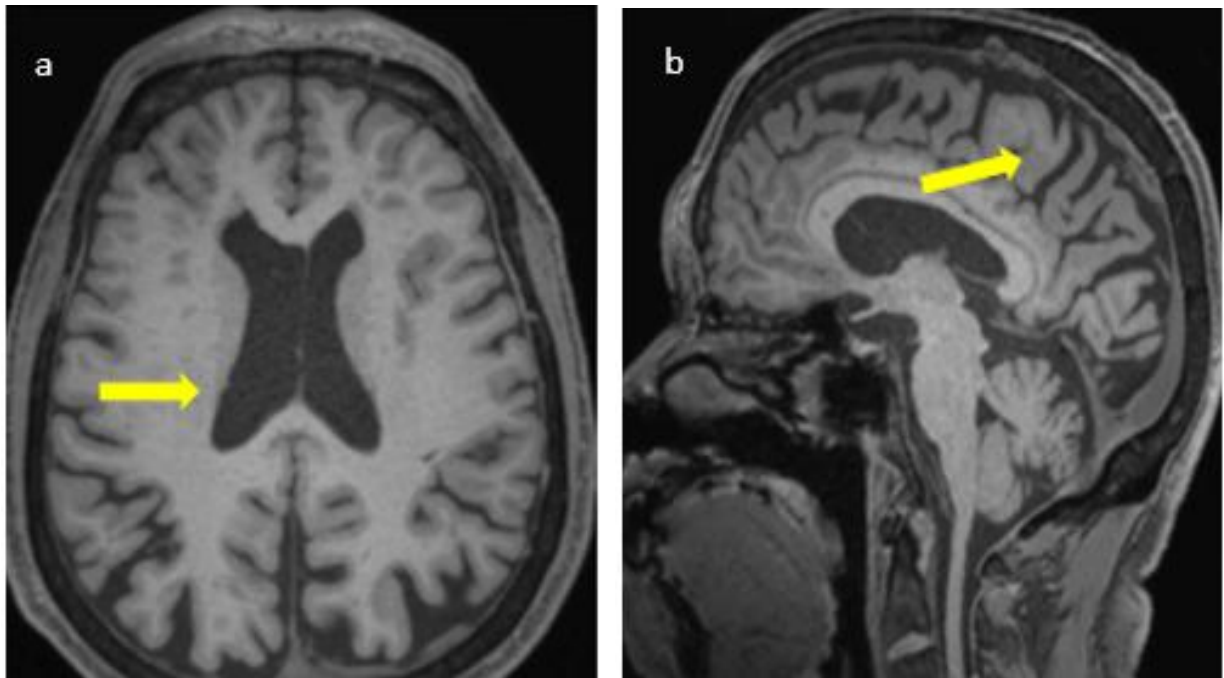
An example of focal brain atrophy. These two figures show signs of cortical atrophy with widened gyri on occipital and parietal T1-weighted images marked with arrows, rated moderate atrophy according to the Global Cortical Atrophy Scale.
